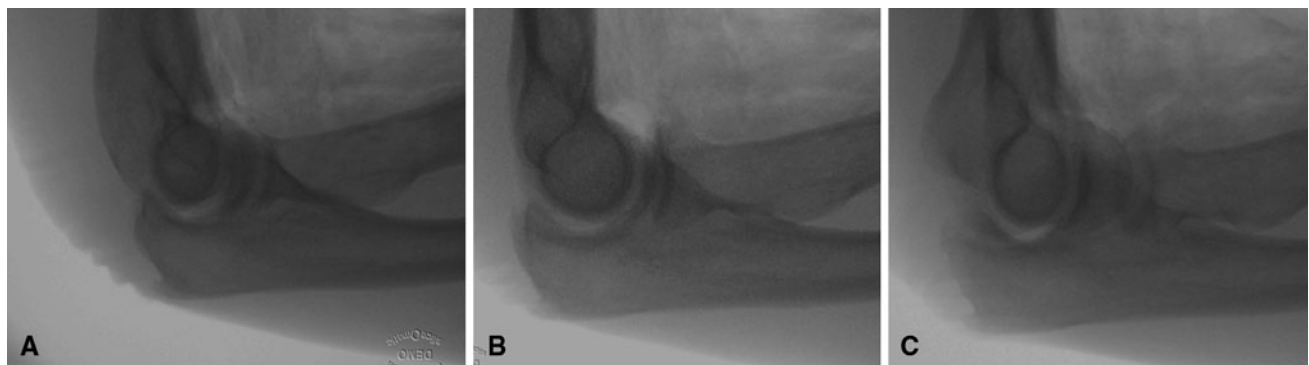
Radiographs of a (A) nonsubluxated elbow with 20° dorsal beam angulation, and (B) the same nonsubluxated elbow in neutral position and (C) with 20° ventral beam angulation are shown.
